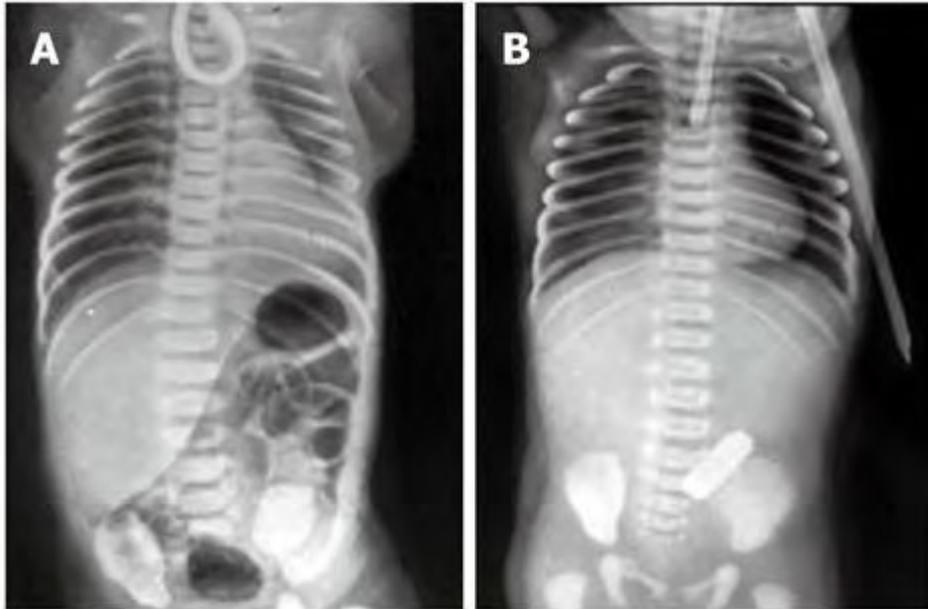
Plain X-rays of the chest and abdomen of two neonates with OA. A: The non-progression of an orogastric tube in the blind oesophageal pouch and the presence of air in the stomach is suggestive of OA with distal TOF; B: The radiopaque tube in the blind oesophageal pouch and the absence of air in the stomach is suggestive of OA without TOF (Reprinted with the Creative Commons Attribution Non-Commercial (CC BY-NC 4.0) license. Pinheiro et al. *World J Gastroenterol.* 2012 Jul 28;18(28):3662-72³
